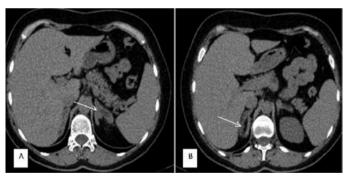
Images of the bilateral adrenal thickening on CT. A: Left adrenal gland, widest thickening 27 mm. B: Right adrenal gland, widest thickening 14 mm
